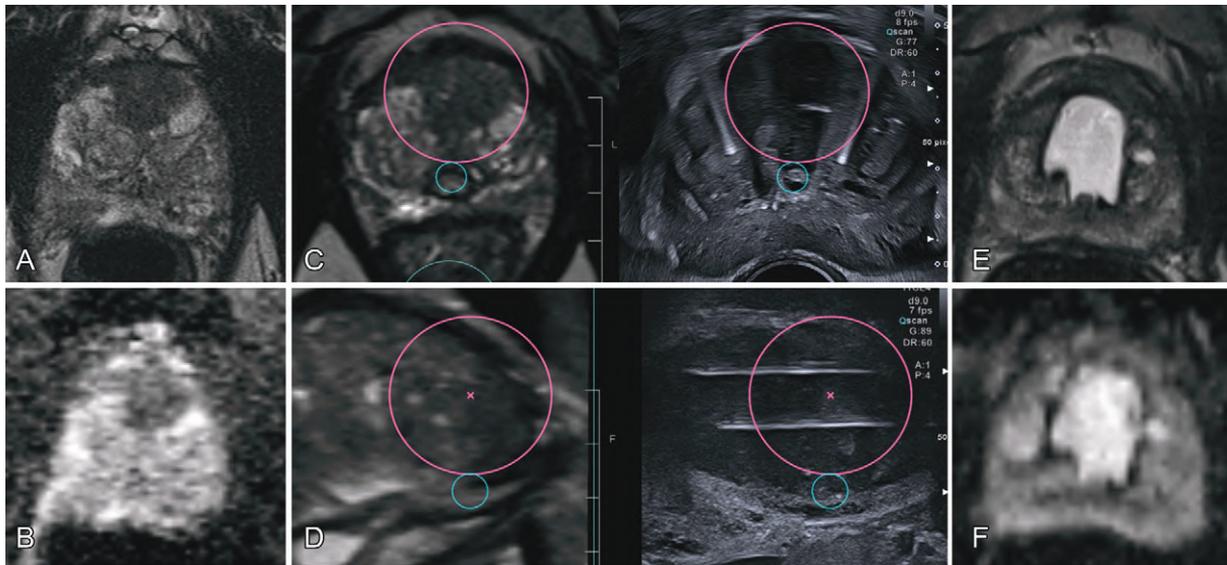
Images in a 68-year-old man with ventrally located Gleason score 3 + 3 tumor treated with irreversible electroporation. *A, B*, Images of baseline unenhanced axial T2- and diffusion-weighted MRI show ventrally located tumor. *C, D*, Unenhanced axial and sagittal MRI-transrectal US-fusion images obtained during procedure show accurate electrode placement in both transverse and sagittal plane to ensure complete enclosure of tumor marked with spherical volume of interest (large pink circle). Small blue circle is anatomic landmark used for image fusion indicating urethra. *E, F*, Images of follow-up unenhanced T2- and diffusion-weighted MRI at 6 months show large fluid-filled defect in anterior aspect of gland with no residual suspected diffusion restriction. Participant experienced prostate-specific antigen level reduction of 60%. Biopsy at 6 months confirmed absence of residual tumor.
